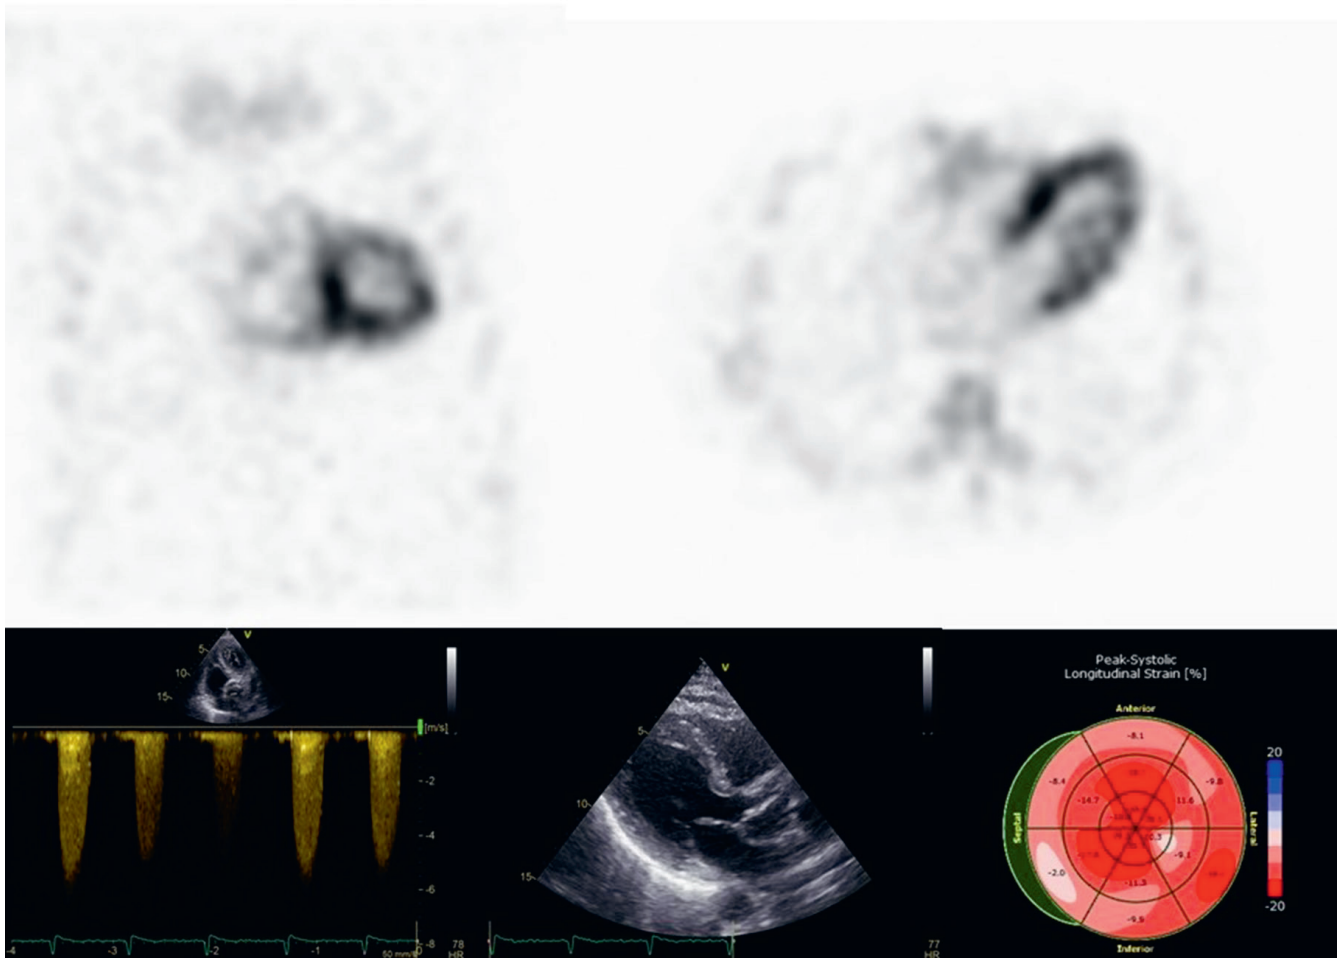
Transthyretin cardiac amyloidosis (ATTR-CA) accompanying aortic stenosis (AS). In the single-photon emission computed tomography (SPECT) test – grade 3 according to the Perugini scale, i.e., strong cardiac uptake and no skeletal uptake of the tracer – a picture typical of ATTR-CA. The echocardiogram shows concentric myocardial hypertrophy, morphological valve changes with a significant mean transvalvular gradient (89 mm Hg), and the impaired deformation of the basal and middle segments of the myocardium
